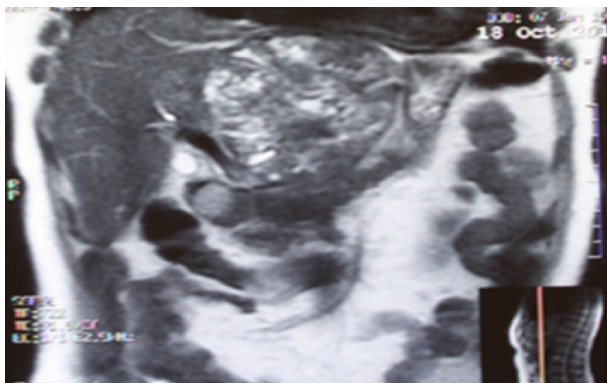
Magnetic resonance imaging of the abdomen: Ill-defined contrast-enhancing, multilobulated cystic lesion involving segments II, III, VI and VIII.
